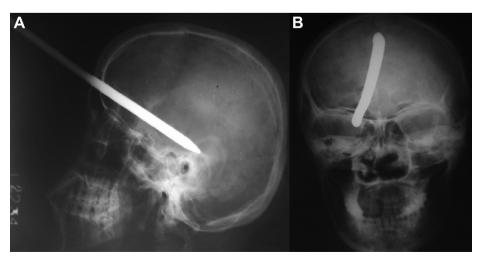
Lateral (A) and anteroposterior (B) skull X-ray showing iron rod inserted in the skull.
